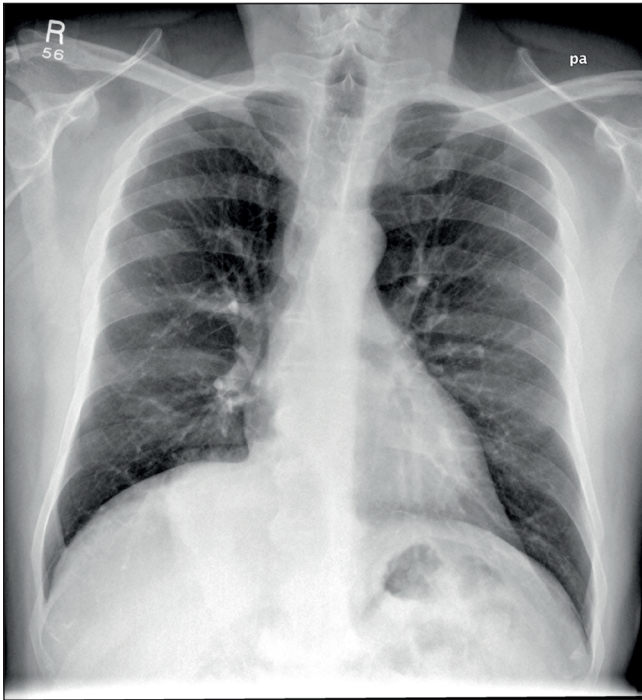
Right Basal Tumour, chest radiograph
